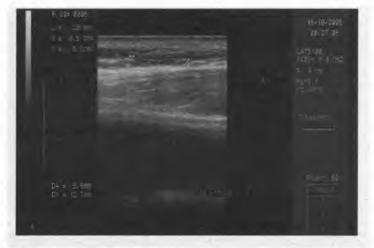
Ultrasonic image of neavum pigmentosum with the lesion size marked
